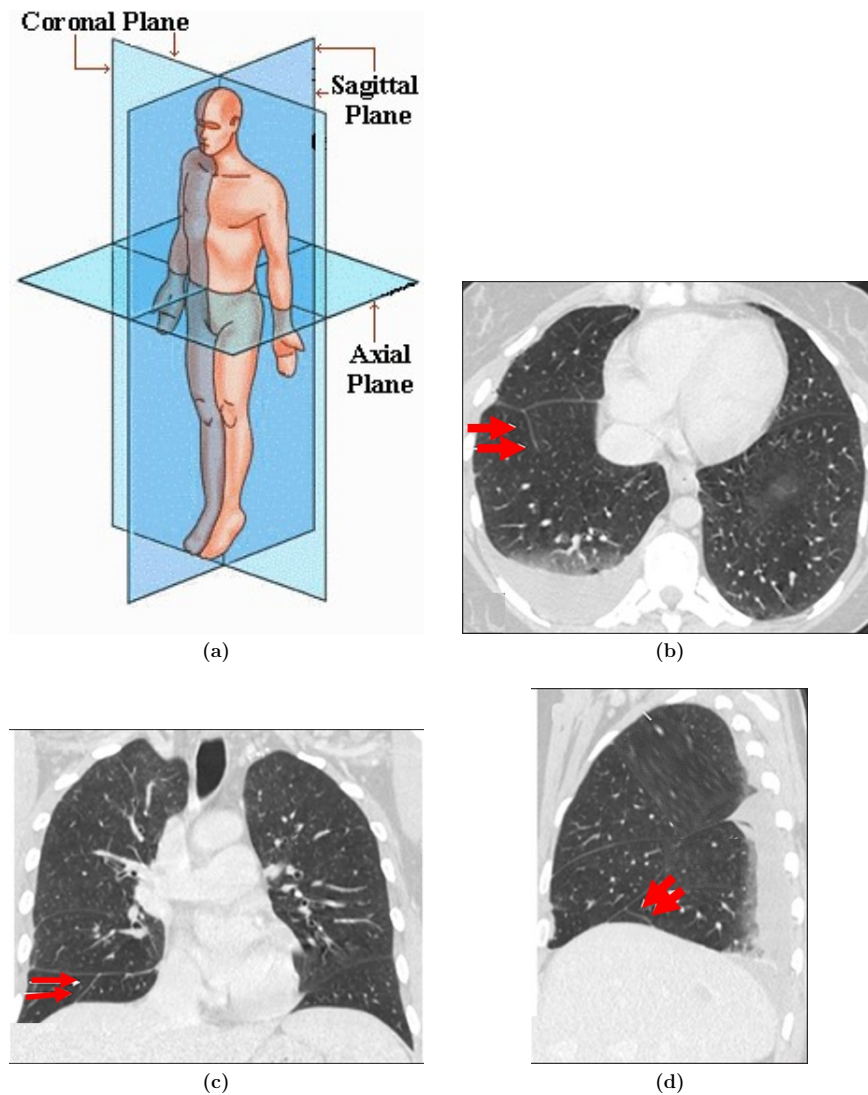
Different viewing planes for a thoracic CT image (a) Planes of the body. From [40] (b) axial view (c) coronal view (d) sagittal view. Double arrows in (b), (c) and (d) show the location of the fissure in the three views. From [41]
